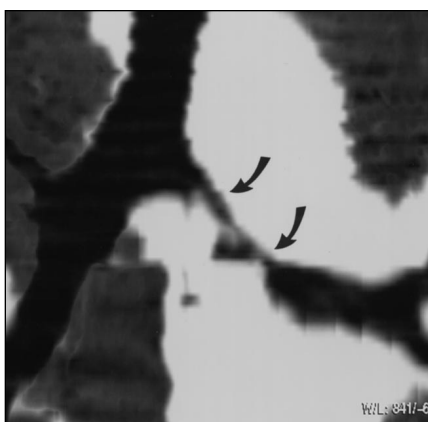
Wegener's granulomatosis in 33-year-old woman. Coronal minimum-intensity-projection image obtained from CT scan (3-mm collimation) delineates two focal strictures (arrows) in diffusely narrowed left main bronchus.
